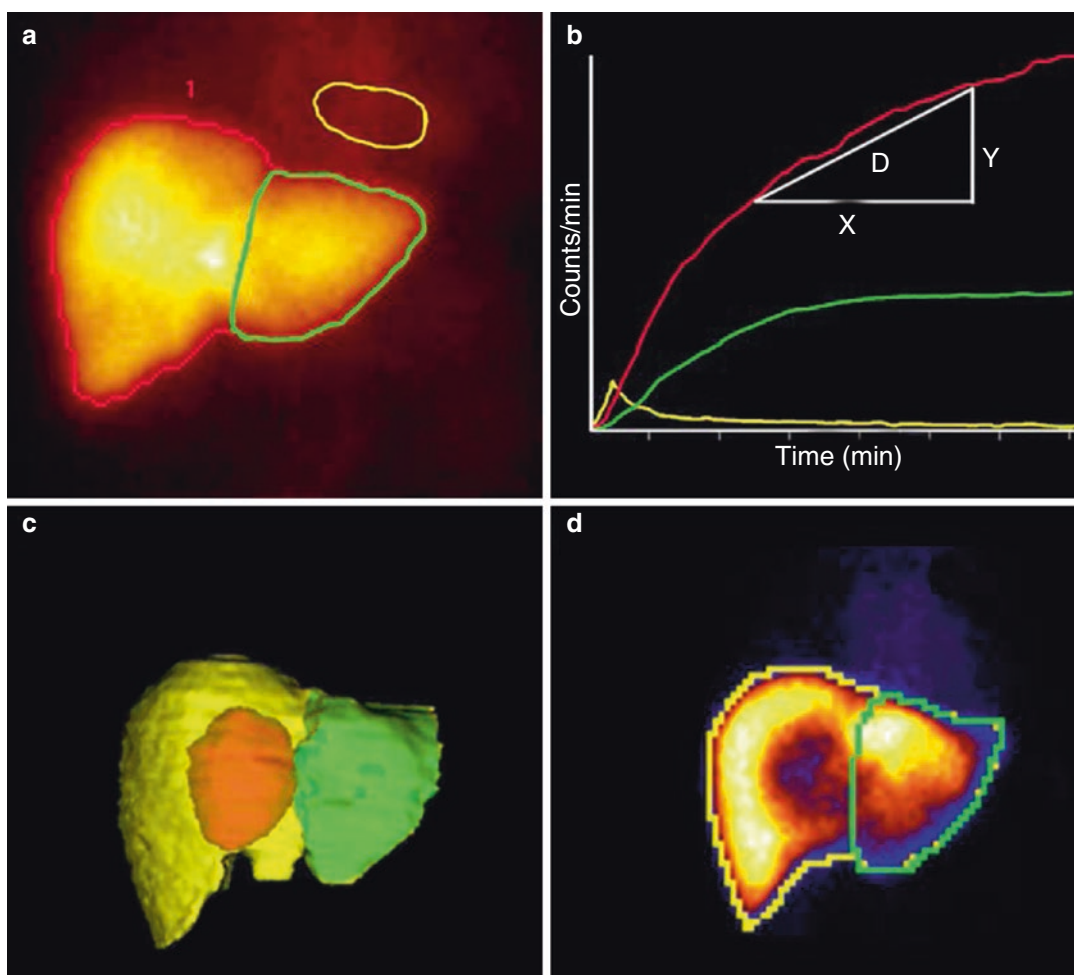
HIDA scan 150–300 seconds after i.v. injection of ^{99m}Tc-mebrofenin (a) revealing a blood pool corrected liver-uptake time-activity curve (b) of the whole liver and the FLR (green). Three-dimensional reconstructed CT images (c) are used to guide identification of the FLR on HIDA scan (d)
